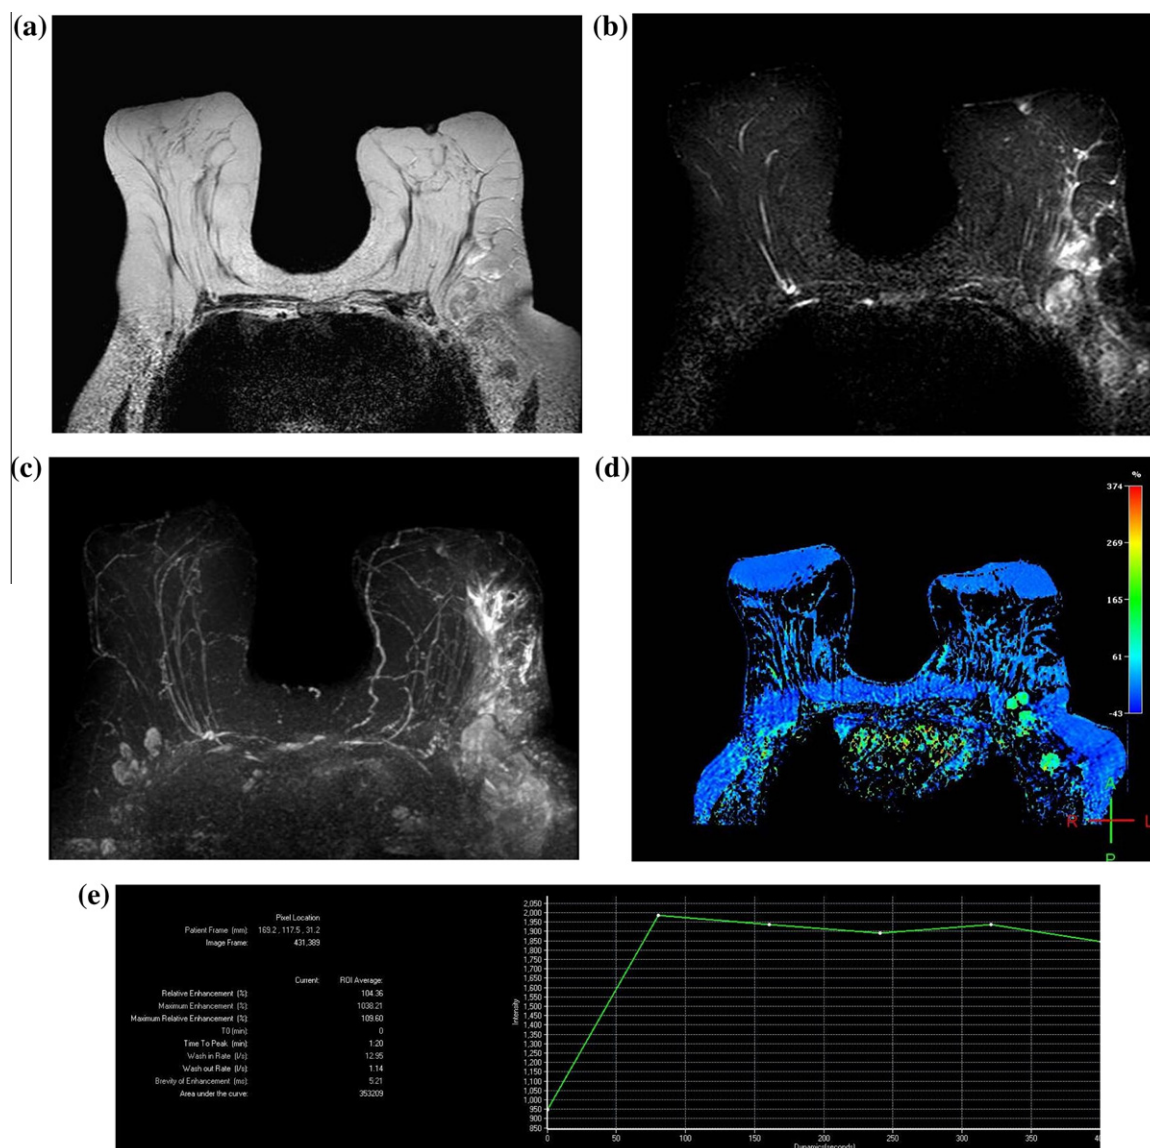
Known case of metastatic non-Hodgkin lymphoma. Axial (a) T2-weighted, (b) T2-STIR and (c) 3D MIP reconstructed T2-STIR show left axillary pathologically enlarged and amalgamated nodes. Ipsilateral upper outer quadrant tissue edema of patchy bright SI. Note the right side benign looking axillary nodes with preserved fatty hilum. (d) Post contrast axial image at 2.4 min of the dynamic series with color overlay. (e) Time/SI analysis of one of the enlarged nodes shows early uptake at 120 s. with corresponding SI% of 109% and type III (early wash out) curve.
